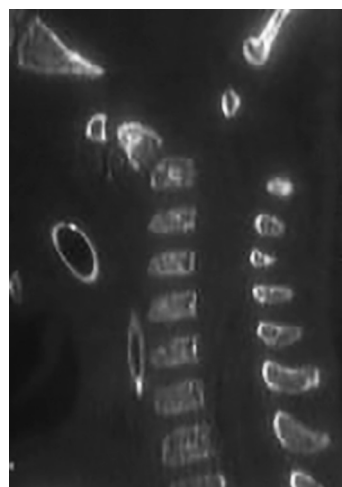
CT scan of cervical spine suggestive of displaced fracture of the base of odontoid. The odontoid is displaced anteriorly with dens tilted posteriorly
